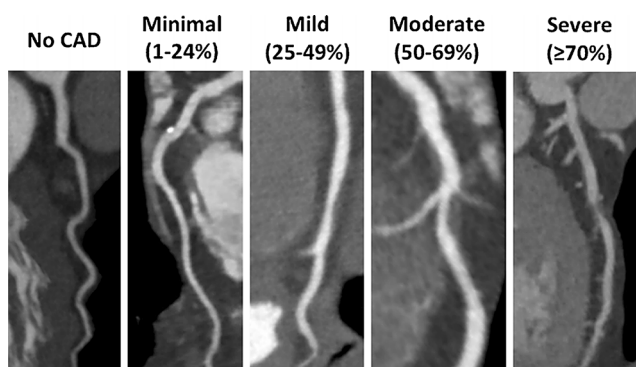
CTA diagnoses the degree of CAD blocking. From reference [156]
